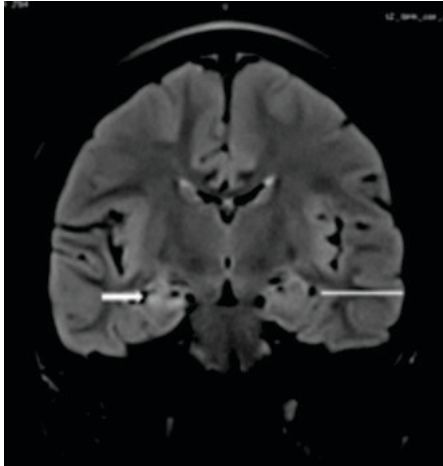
Small deformed FLAIR hyperintense right hippocampal formation (shown by white broad shorter arrow) with relative widening of temporal horn of right lateral ventricle on FLAIR coronal image in young teenager male with epileptiform seizures- Right mesial temporal sclerosis. Left normal hippocampus is shown by long white arrow.
